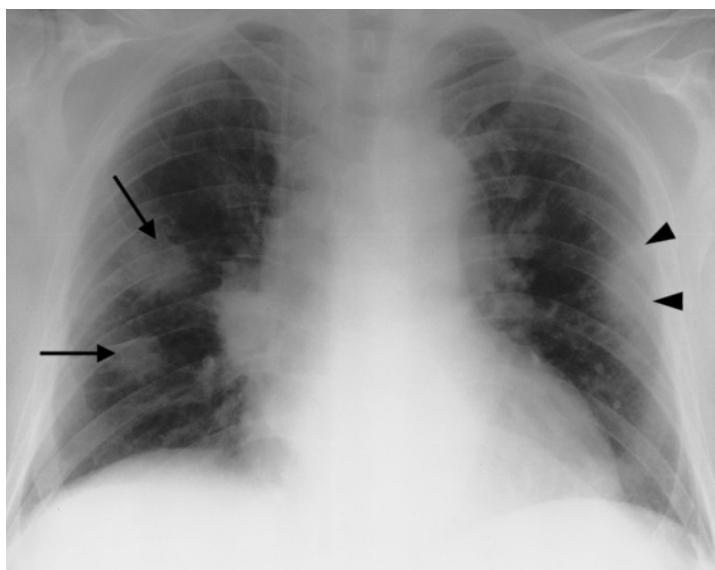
Wedge-shaped infiltrate in invasive aspergillosis. The patient is a 57-year-old man with Wegener granulomatosis receiving immunosuppression therapy. He has an antibiotic-resistant fever. The radiograph shows focal infiltrates (black arrows) with broad pleural contact in the left upper lung field (black arrowheads).
